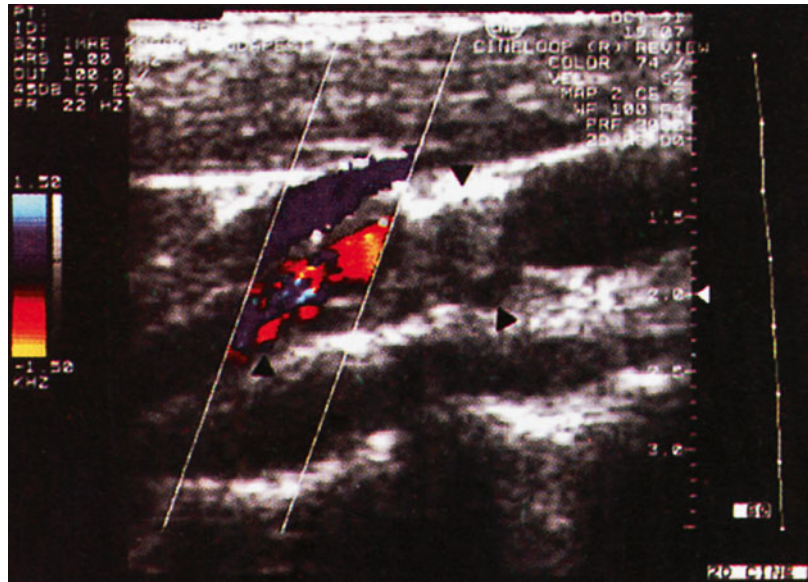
The bifurcation and the origin of the internal and external carotid arteries are seen in the color Doppler image. The flow is diverted due to a small mural lesion (*arrowhead*) at the origin of the internal carotid artery
